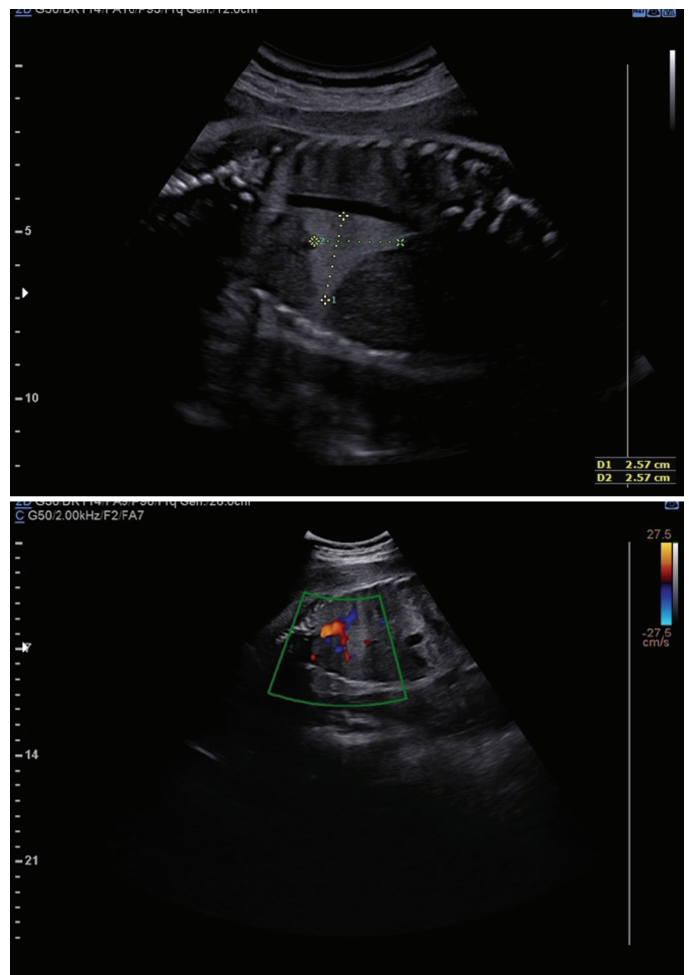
Ultrasonographic image of bronchopulmonary sequestration and its systemic vascular supply
